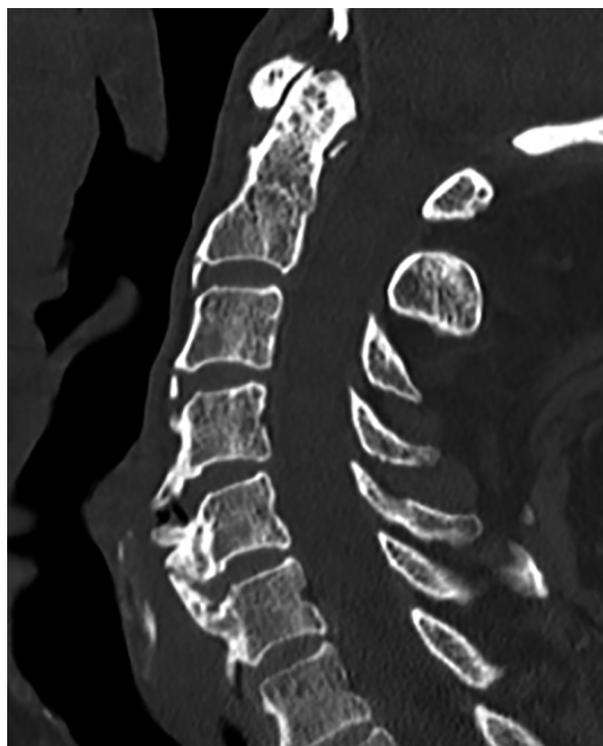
CT scan of a 71-year-old man whose dysphagia was induced by a C4/C5 C5/C6 degenerative osteophyte whose instability was evidenced by a vacuum image.
